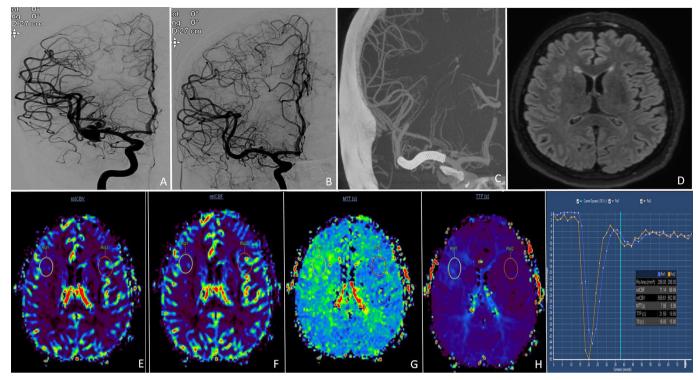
Patient 9. Digital subtraction angiography (DSA) with anterior—posterior view (A) showing a trilobulated aneurysm of the right middle cerebral artery (MCA) bifurcation. Two-year follow-up DSA with anterior—posterior view (B) and flat detector computed tomography angiography (FDCTA) image (C) demonstrating the complete occlusion of the aneurysm with the luminal patency of the stent, which extends from the MCA M1 segment to the proximal MCA M2 segment inferior trunk. The MCA superior trunk (white arrow) is shown to be slightly reduced in caliber on DSA with an anterior—posterior view (B). Axial fluid-attenuated inversion recovery (FLAIR) image (D) revealing the absence of any ischemic lesion related to the territory associated with the MCA superior trunk that is jailed after flow diverter stent treatment. Relative cerebral blood volume (rCBV) (E), relative cerebral blood flow (rCBF) (F), mean transit time (MTT) (G), time-to-peak (TTP) (H) maps and measurement results (I) are shown on dynamic susceptibility contrast (DSC) magnetic resonance perfusion images. An increase in TTP and MTT and a decrease in rCBF are observed in the jailed right MCA superior trunk territory.
